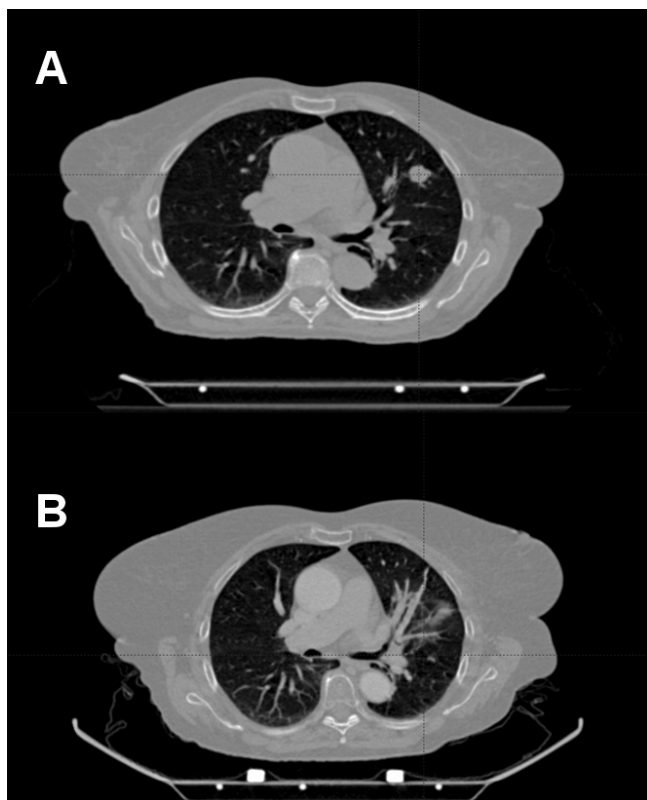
(A) The CT image of the patient with a lung metastasis before SRT. (B) The CT image of the same patient showing a complete regression after SRT with 3 x 20 Gy
